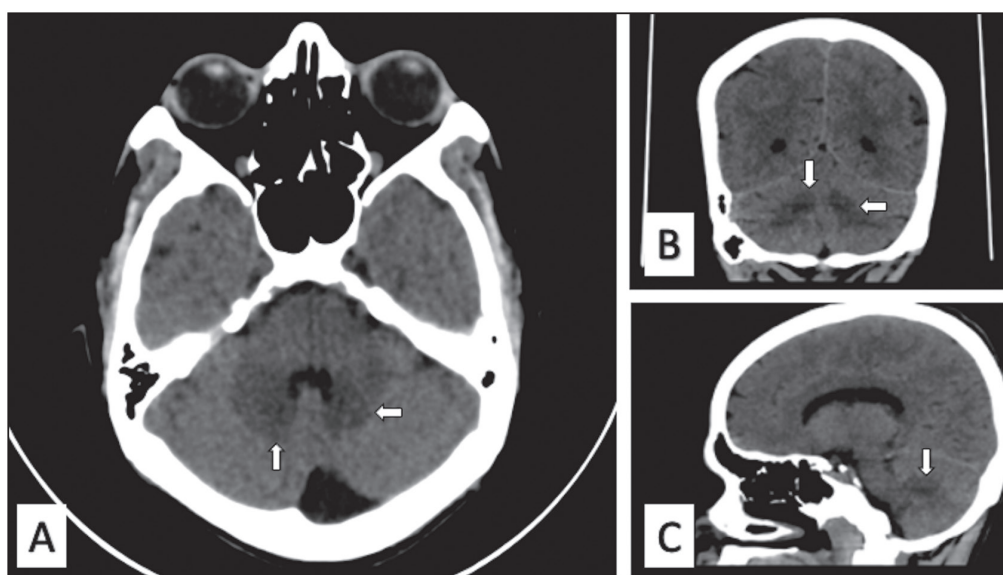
Noncontrast computed tomography (NCCT) brain in axial (A), reconstructed coronal (B), and sagittal sections (C) showing confluent hypodensity in the dentate nucleus of bilateral cerebellar hemisphere (white arrows). No signs of mass effect/compression were noted
